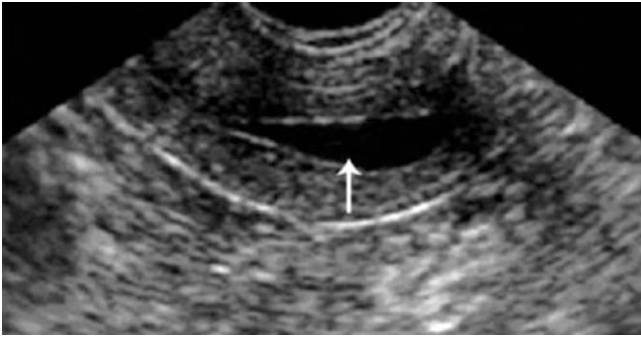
Uterine effusion. A woman with a postmenopausal period of 3 years represented with abnormal vaginal discharge. Sonogram shows the atrophied uterus, the clear fluid in the uterine cavity (1.6 cm in diameter), and the smooth inner wall of the uterus (arrow)
